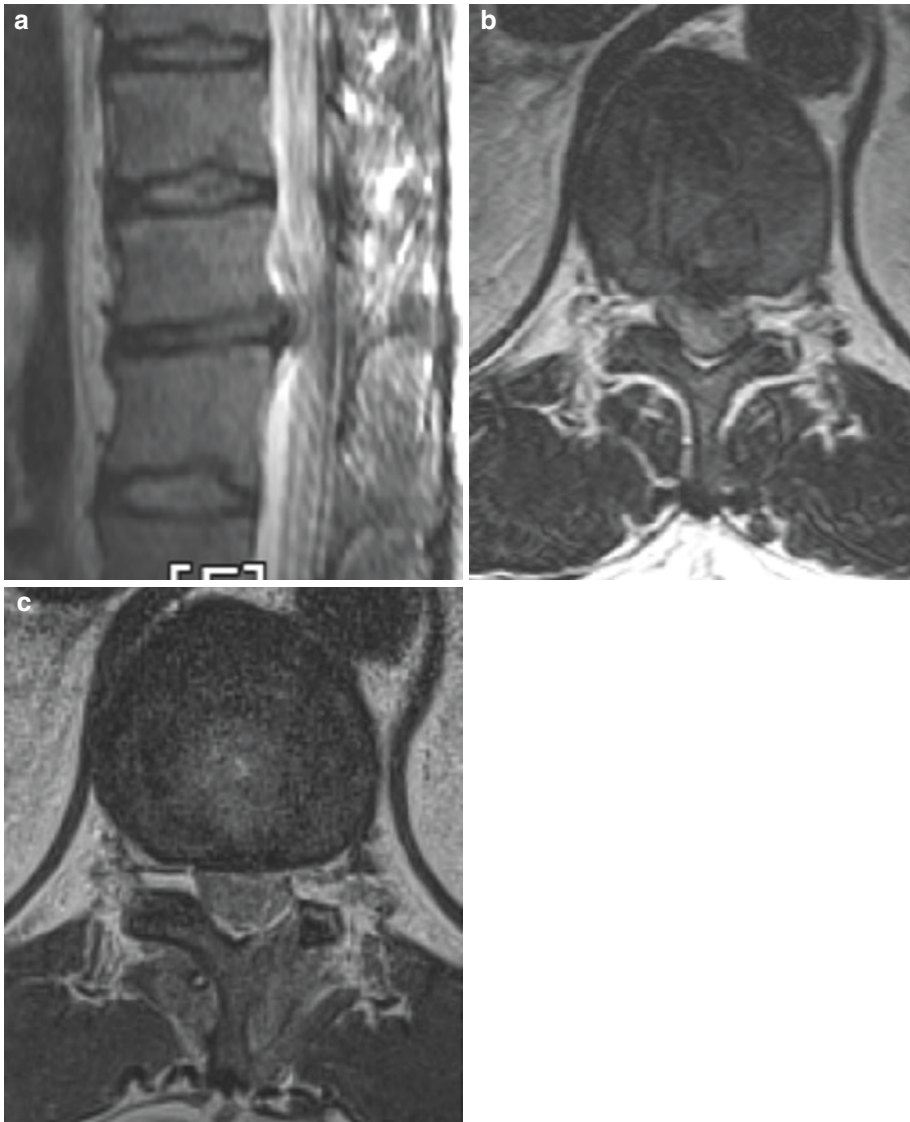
Magnetic resonance (MR) image of a soft disc herniation at the T11/12 level. (a) Preoperative T2-weighted sagittal MR image demonstrating soft disc
